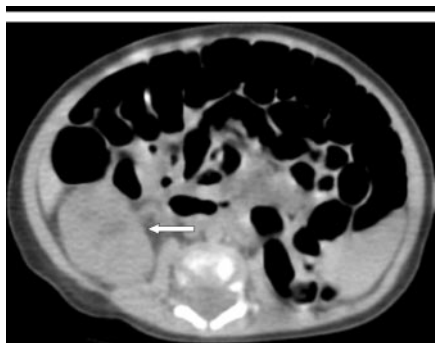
Transverse nonenhanced computed tomographic (CT) scan of the midabdomen of a 1-month-old baby who was born with a single kidney (arrow). His mother, victim of a terror explosion in a bus, was hospitalized elsewhere but was able to identify the baby by remembering from a prenatal sonogram that the baby had a single kidney.
